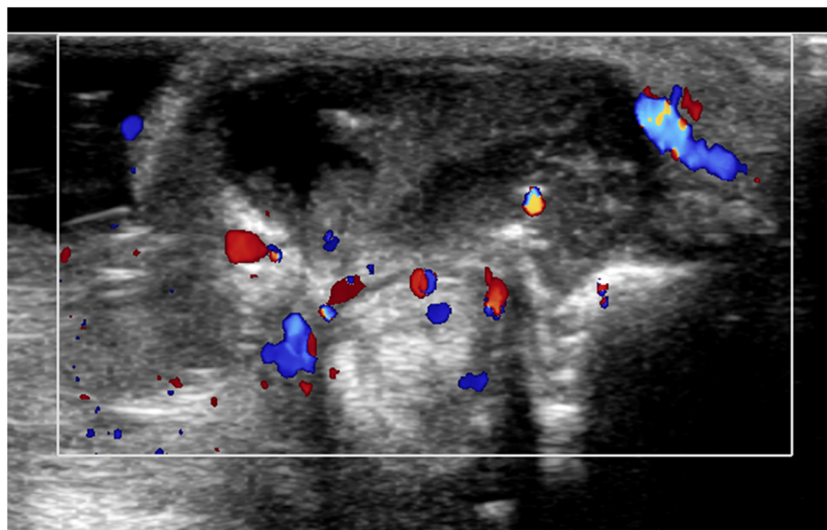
Axial Doppler US image
